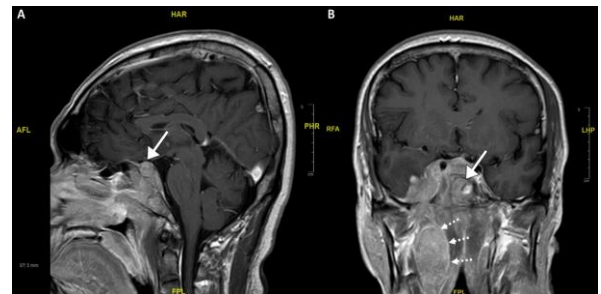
A.-B. MRI brain showed right cavernous sinus mass with intracranial extension, with pituitary gland and sellar involvement (arrows). B. Right nasopharynx enhancing mass was seen in the visualized upper neck region (dotted arrows).
